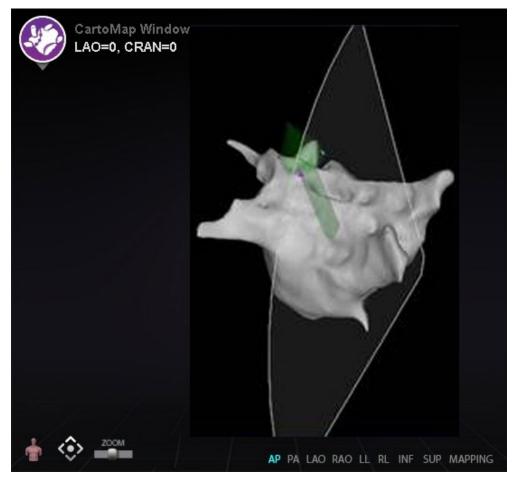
Ultrasound Fan display in CartoMap Window example
